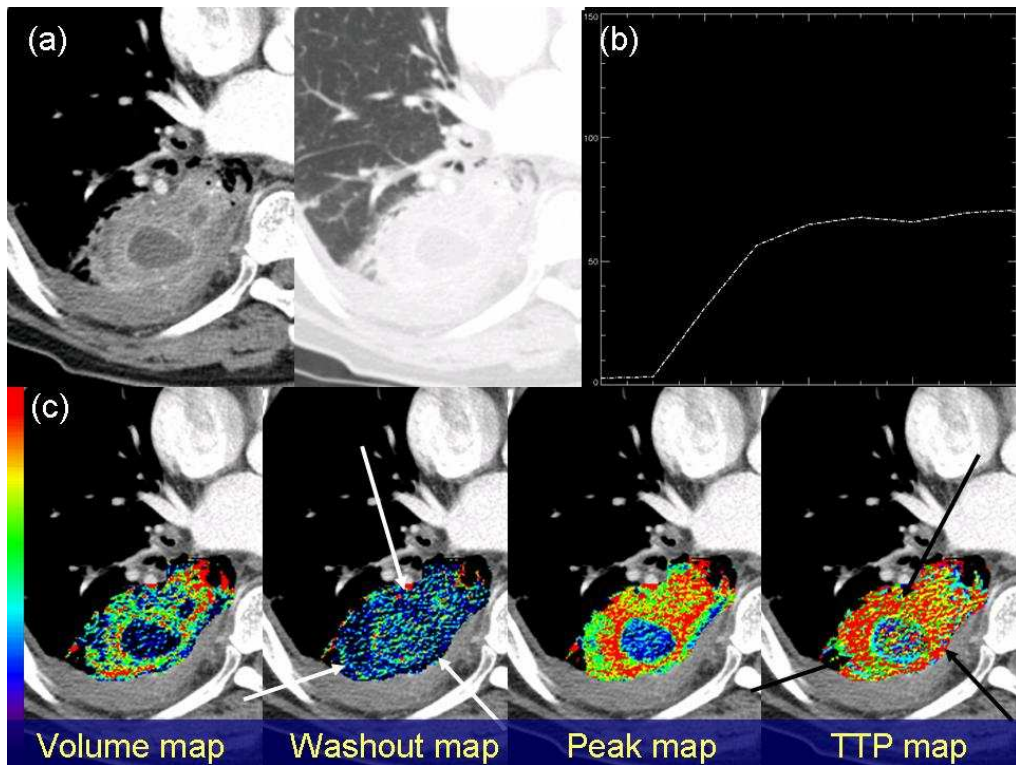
Chest CT and parametric perfusion maps in a 55-year-old man with a lung abscess in the right lower lobe superior segment.
